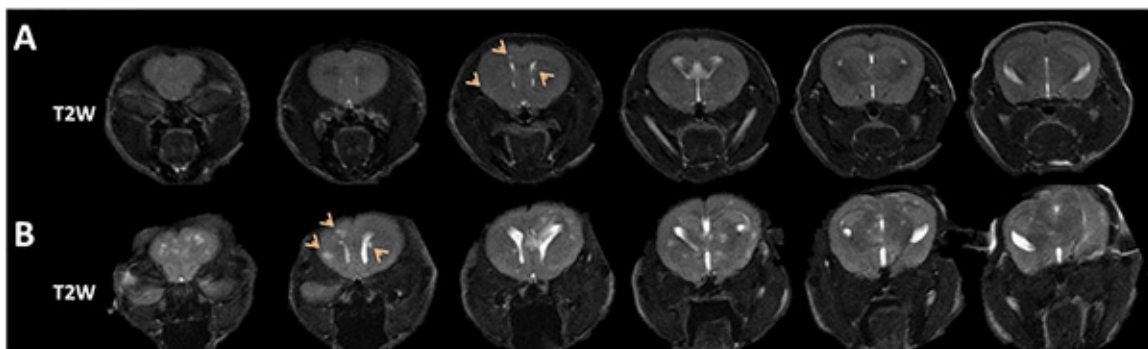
Longitudinal MRI of development of brain metastases. A. Six consecutive coronal MRI sections at week 3 identified multiple lesions with hyper-intensity on T₂-weighted images. B. An increased number of lesions appeared on the images at week 4, and those lesions seen on week 3 became larger. [Click here to view larger image.](#)
